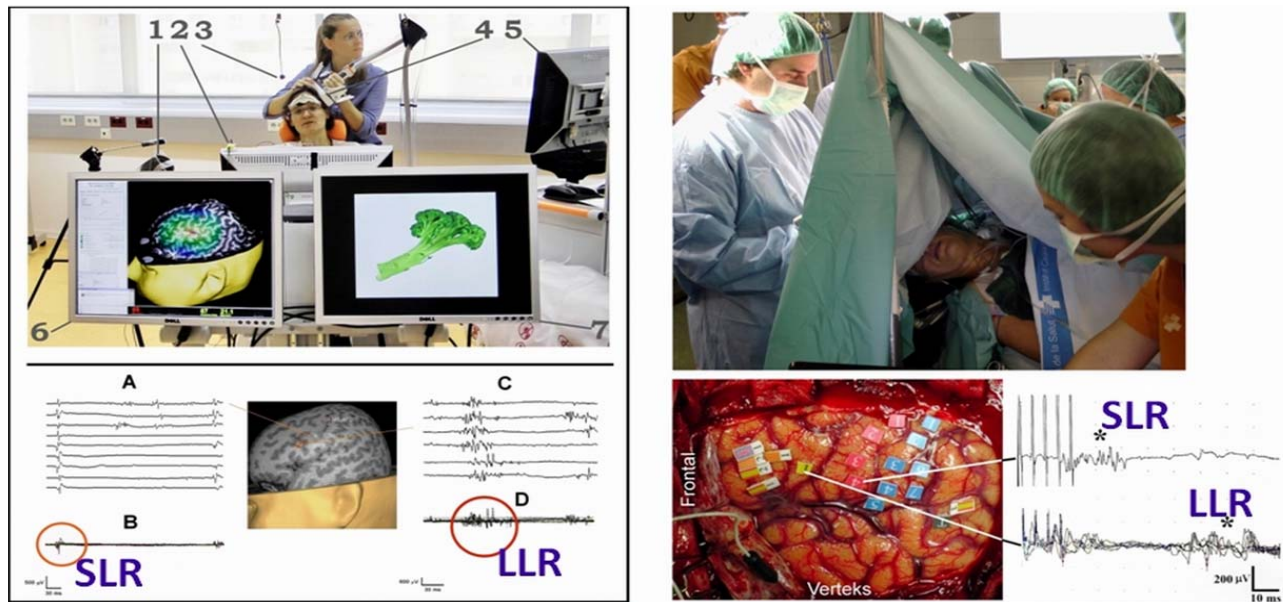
Left up: Subject during naming visually presented object and examiner holding the coil over on the dominant hemisphere with stimulation localized over the opercular part of Broca's area (Legend: 1=microphone connected to EMG amplifier, 2=monitor with visual object presented to the subject and the attached photo sensor, 3=microphone connected with the video camera, 4=magnetic coil for nTMS, 5= monitor with MRI for precise determination of stimulation site, 6=cloned monitor 5 for video shooting, and 7= cloned monitor 2 for video shooting). Left down: Neurophysiologic markers of M1 for laryngeal muscles (SLR) and of opercular part of Broca's area (LLR) for one subject Left: A) Repeatability of SLR and B) superimposed SLR; Right: C) Repeatability of LLR and D) superimposed LLR. In the Middle: 3D MRI with localisation of stimulated spots. Right: The results of intraoperative cortical mapping. Stimulation of the cortical spot marked in red (4) elicited SLR, while cortical spot marked in yellow (1) elicited LLR in cricothyroid muscle. From the same spot where LLR was elicited, speech arrest was induced for Spanish. (T=tumor location; Blue markers 1-7=somatosensory cortex; Red markers 1-4 primary motor cortex; Asterisks to the right depict SLR and LLR.
